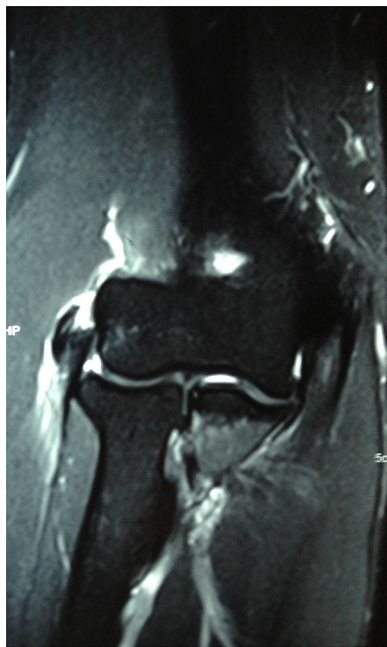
Magnetic resonance imaging of coronal section showing a lesion with tearing of the short radial extensor tendon.
